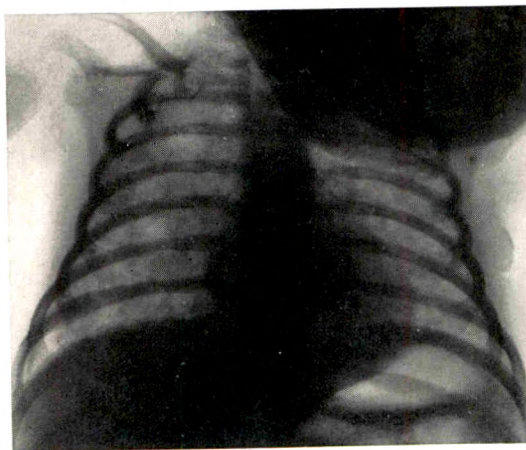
Case II. Necropsy roentgenogram. Large irregular shadows produced by hemorrhages coalescing to produce whorl-like patterns. Note similarity to certain cases of bronchopneumonia (Fig. 5).
